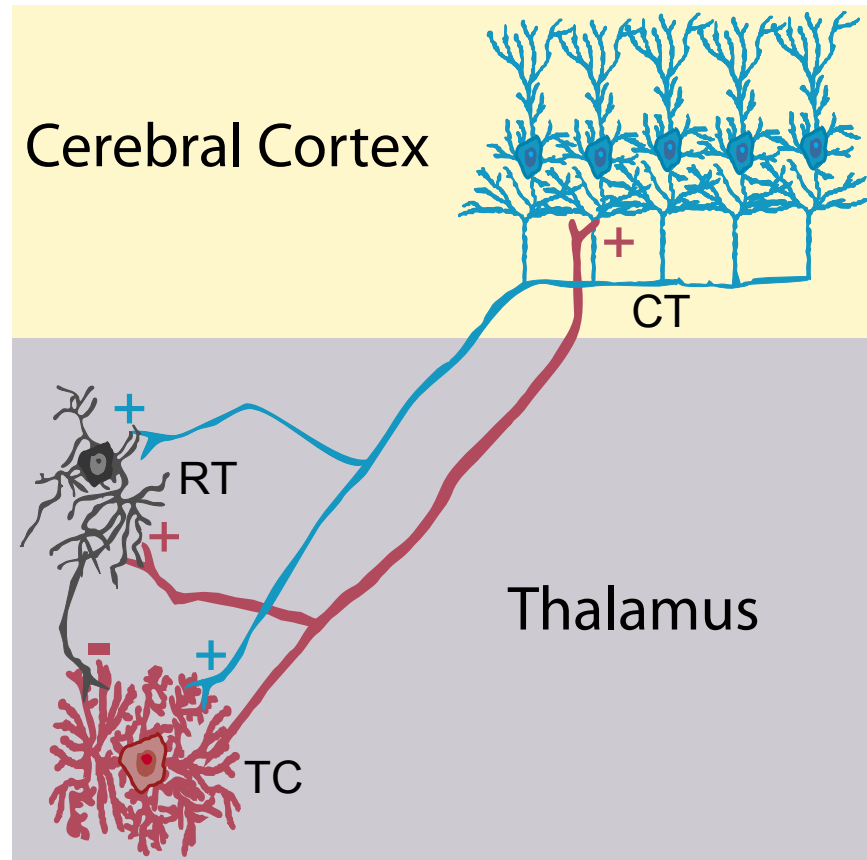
Thalamic and cortical neurons involved in the thalamocortical circuit. This figure shows the neurons involved in the thalamocortical circuit: corticothalamic (CT), reticulothalamic (RT), and thalamocortical (TC) neurons. The plus symbol corresponds to excitatory synapses (i.e., releasing the neurotransmitter glutamine) and the minus symbol corresponds to inhibitory synapses (i.e., releasing the neurotransmitter GABA).
